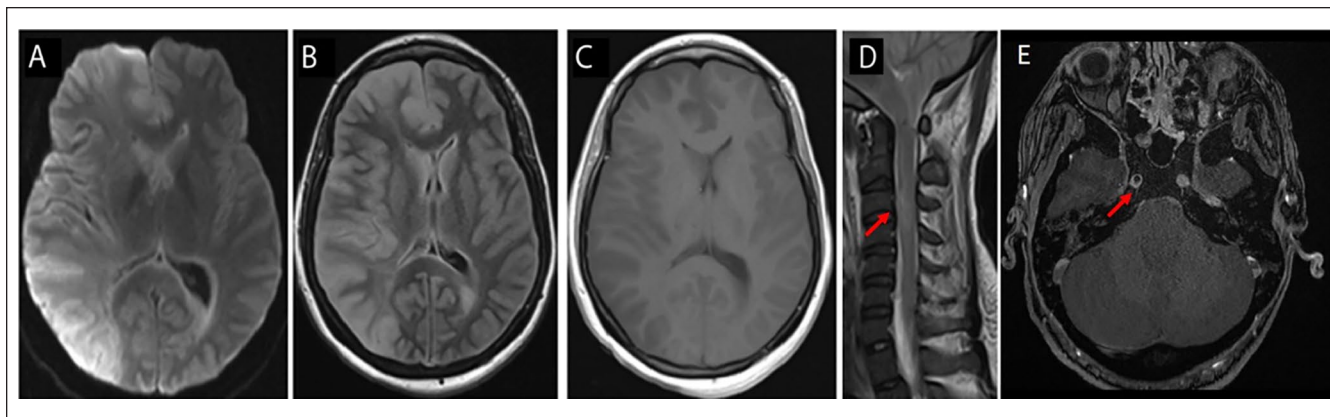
Patient 2 had right cerebral hemispheric restricted diffusion (diffusion-weighted imaging in panel A) and cerebral edema (fluid-attenuated inversion recovery [FLAIR] in panel B) affecting gray matter and deep gray nuclei, without enhancement (panel C), and spinal edema (shown with arrow, panel D), and an occlusive thrombus in the right internal carotid artery (shown with arrow, panel E).
